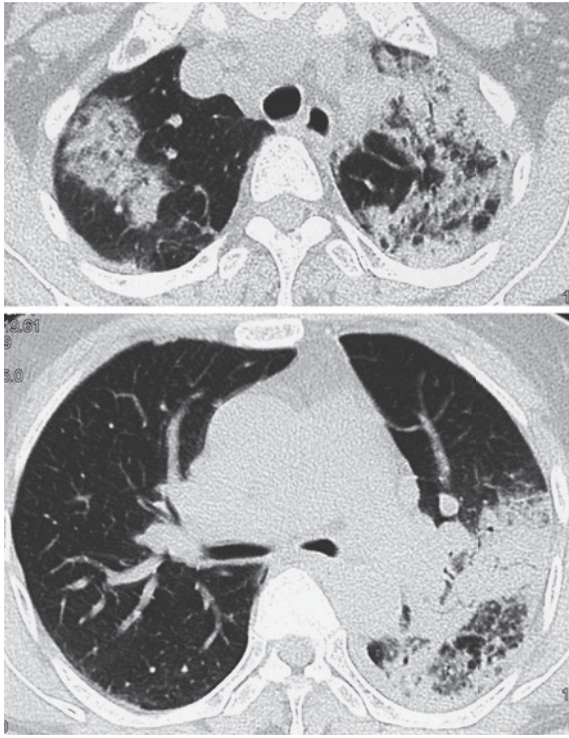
Computed tomographic scans of the chest, showing areas of patchy nonsegmental airspace consolidation bilaterally.
